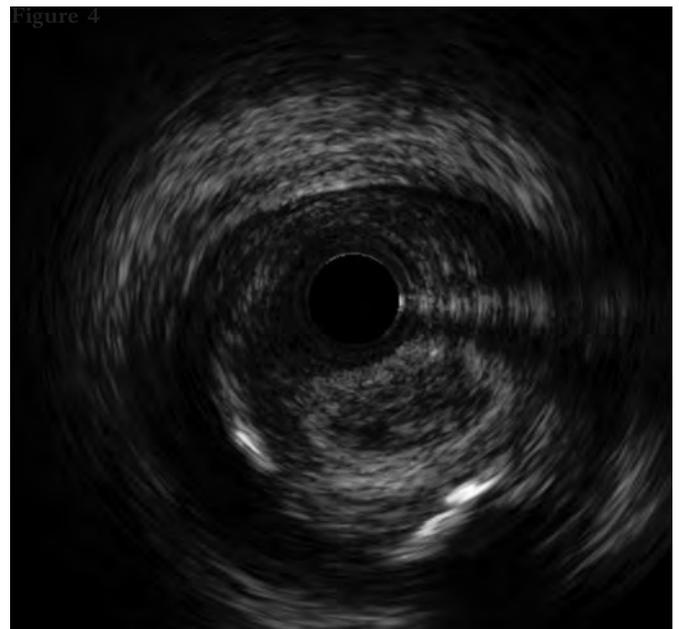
The catheter of intravascular ultrasound in the subintimal space is between the 9 and 12 o'clock positions and true lumen between the 3 and 9 o'clock positions.
